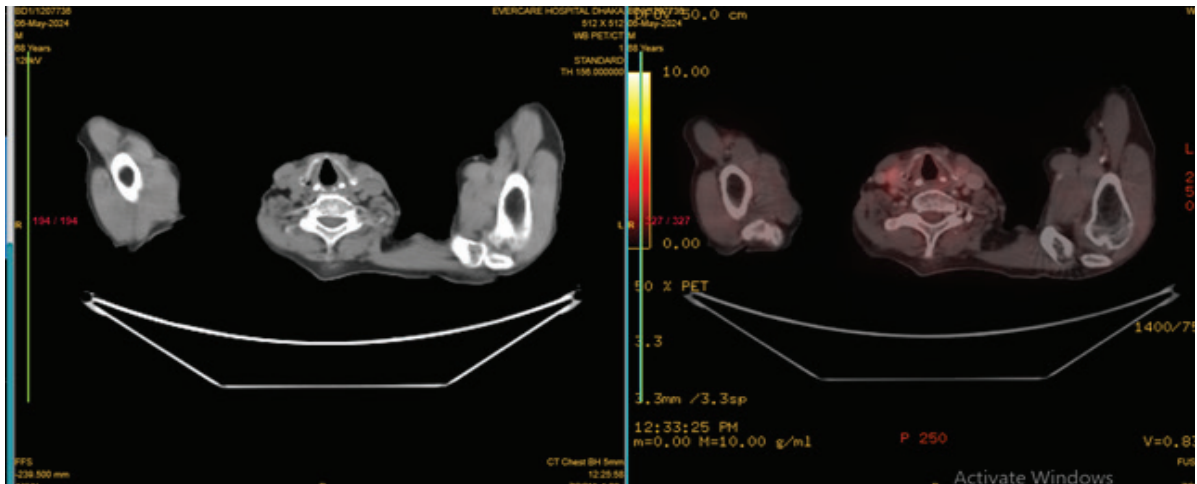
In axial scan, no abnormal FDG uptake is seen in larynx.
